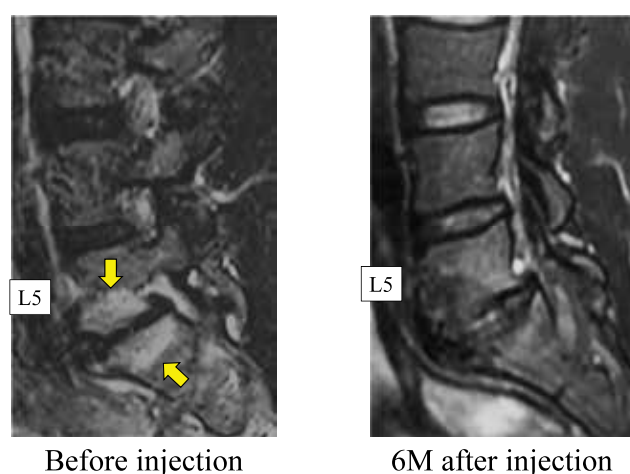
STIR-MRI before and after steroid injection
